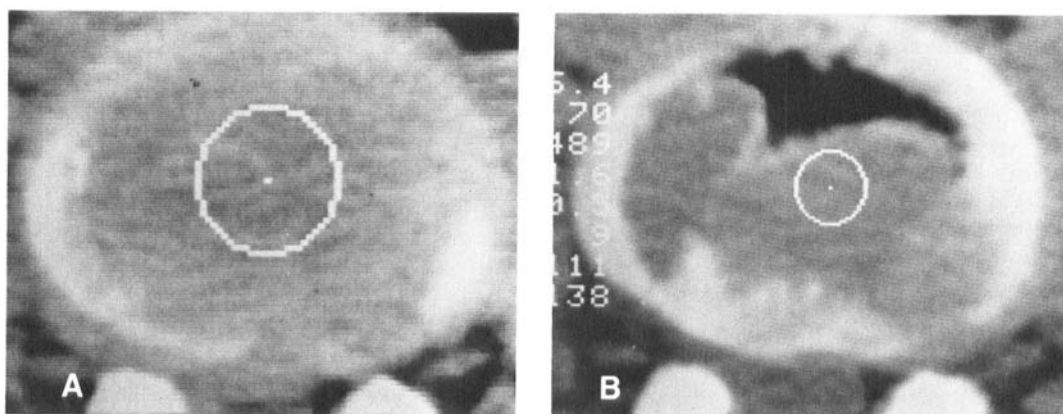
CT of the third lumbar disc in Case 3, 3 weeks (A) and 6 months (B) after the onset of postoperative discitis. In the early CT the disc material had the low density of 36.4 Hounsfield Units (HU). In the late CT islets of bone indicate uneven end plates, the black area vacuolization of the disc, and the density of the disc material itself was 76.4 HU, i.e. in the normal range.
